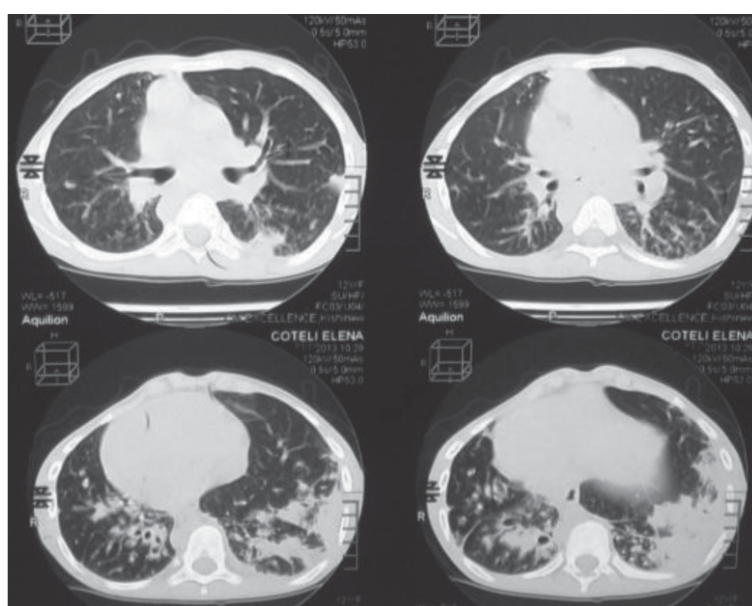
Computed tomography of the *patient C.*, performed on October 29, 2013. For further explanations, see text
